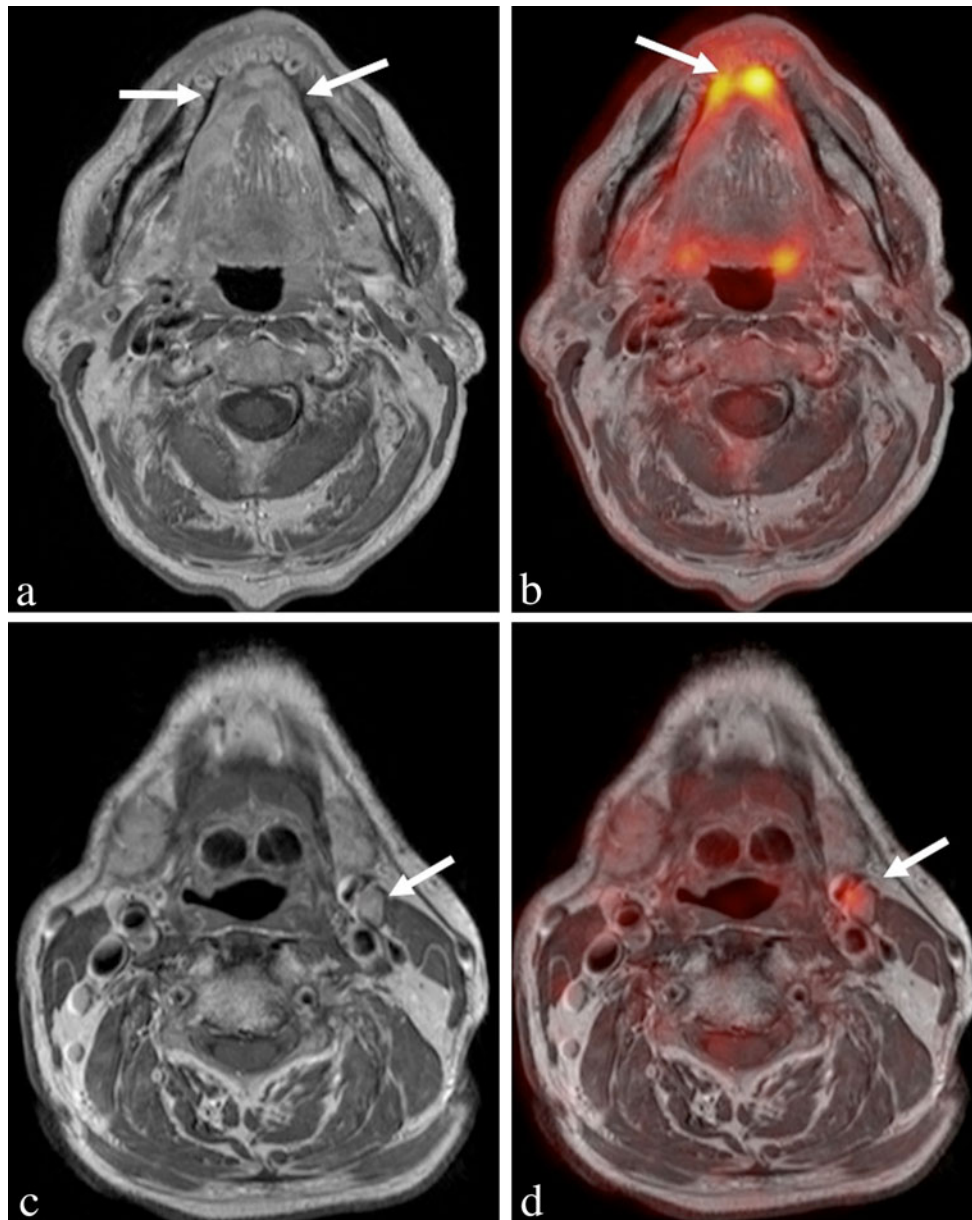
PET/MRI with FDG obtained in a patient with a tumor of the mouth floor. The contrast enhanced T1-weighted MR images are shown in a, whereas the image fusion between the T1-weighted images and the PET acquisition is shown in b. The tumor invades the anterior floor of the mouth bilaterally (*arrows*) extending into the sublingual spaces and the geniohyoid muscles. There is an abnormal
